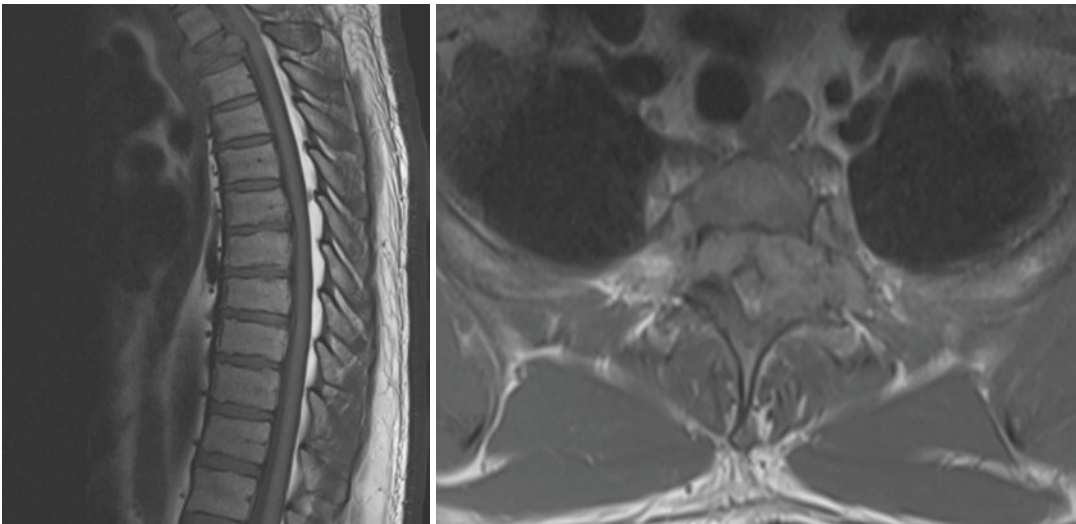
Sagittal and axial T1 MRI demonstrate metastatic RCC pathologic compression fracture of the T2 vertebral body with dorsal bony retropulsion resulting in spinal stenosis and cord compression
